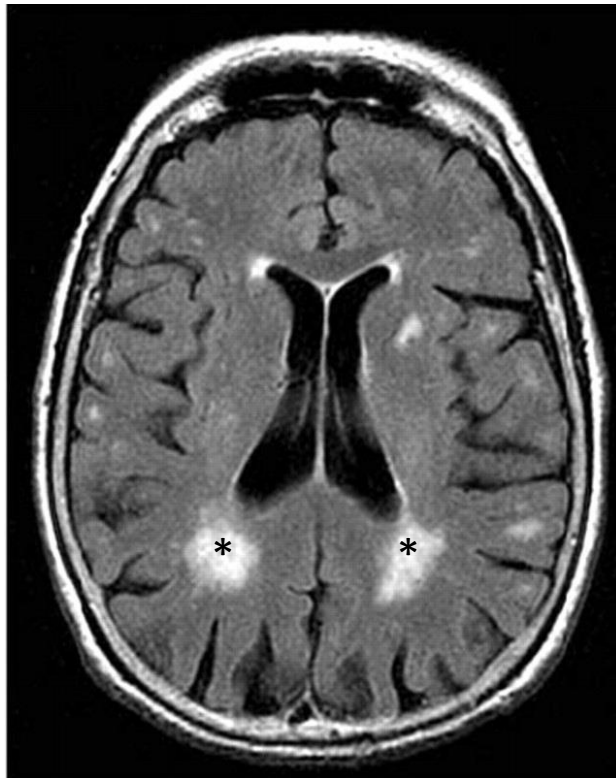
White matter hyperintensities*. Image of a MRI scan from an 80 year old individual, white matter lesions are showing as hypersintensities (asterisks). Image reproduced from Debette and Markus (2010).
